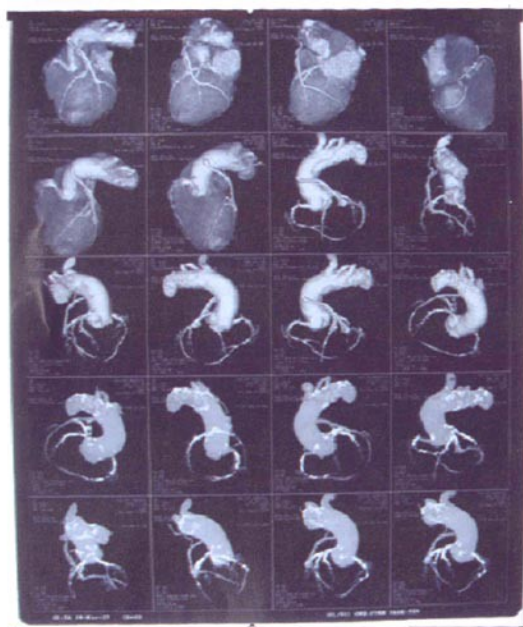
Computed tomography angiography of coronary artery
